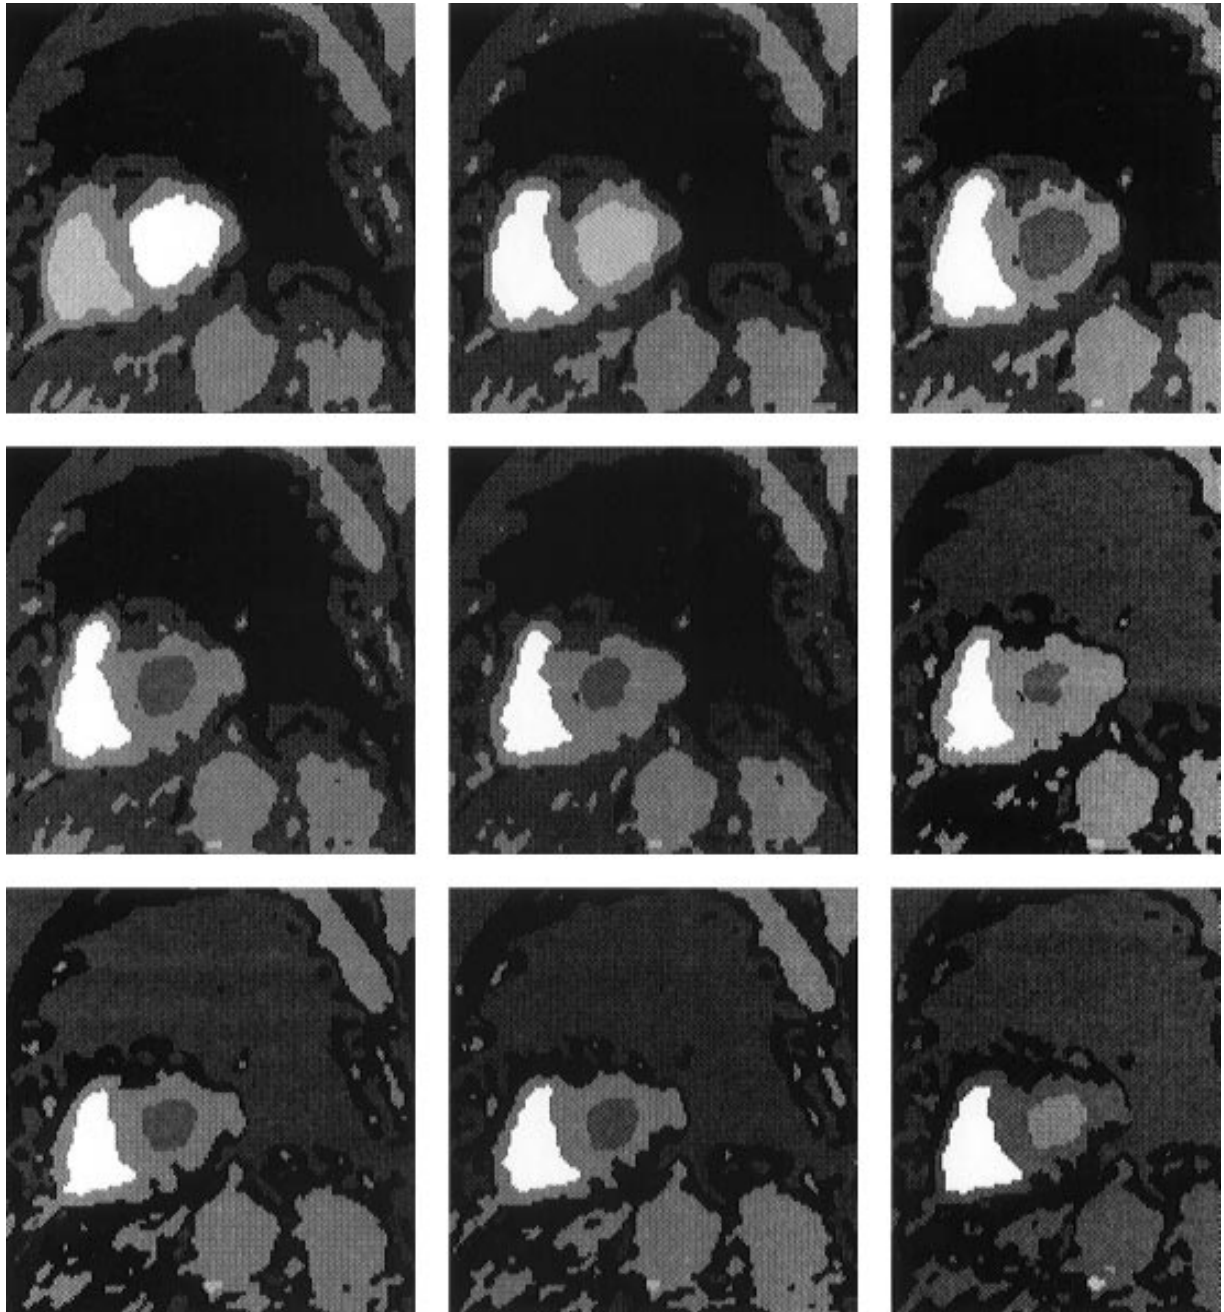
Fuzzy clustering results of a sequence of nine filtered MR images.
